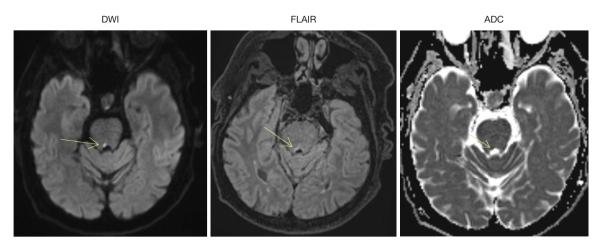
Non-contrast MRI with DWI, FLAIR, and ADC sequences. The yellow arrows point to an apparent diffusion restriction in the tegmentum on the border between the mesencephalon and pons with a hyperintense signal on the FLAIR sequence (DWI-FLAIR match) and hypointense signal on the ADC sequence thus representing a subacute lacunar infarct in the medial longitudinal fasciculus. DWI, diffusion-weighted imaging; FLAIR, fluid-attenuated inversion recovery; ADC, apparent diffusion coefficient; MRI, magnetic resonance imaging.
